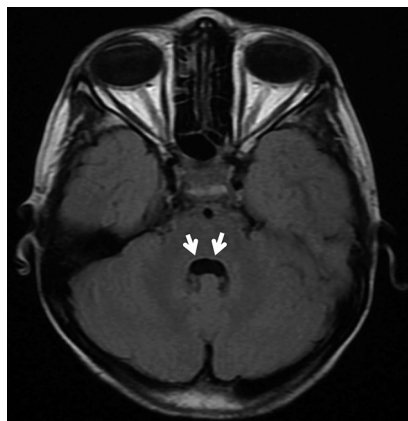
Axial T2 FLAIR showing flattening of fourth ventricle suggesting absence of facial colliculus
